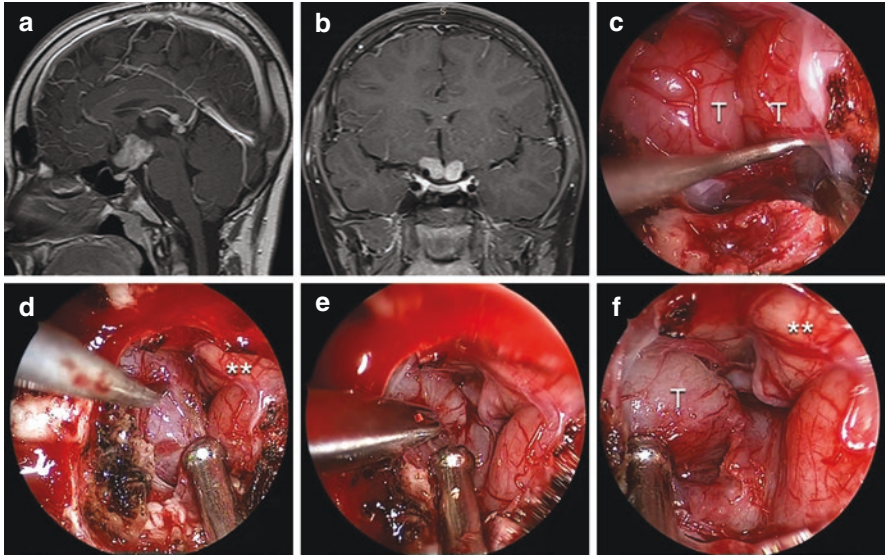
Suprasellar GCT. Preoperative MR images (a, b). Operative views (c–f) during tumor biopsy via an endoscopic endonasal transtuberculum sellae approach. T, tumor; double asterisks, optic chiasm
